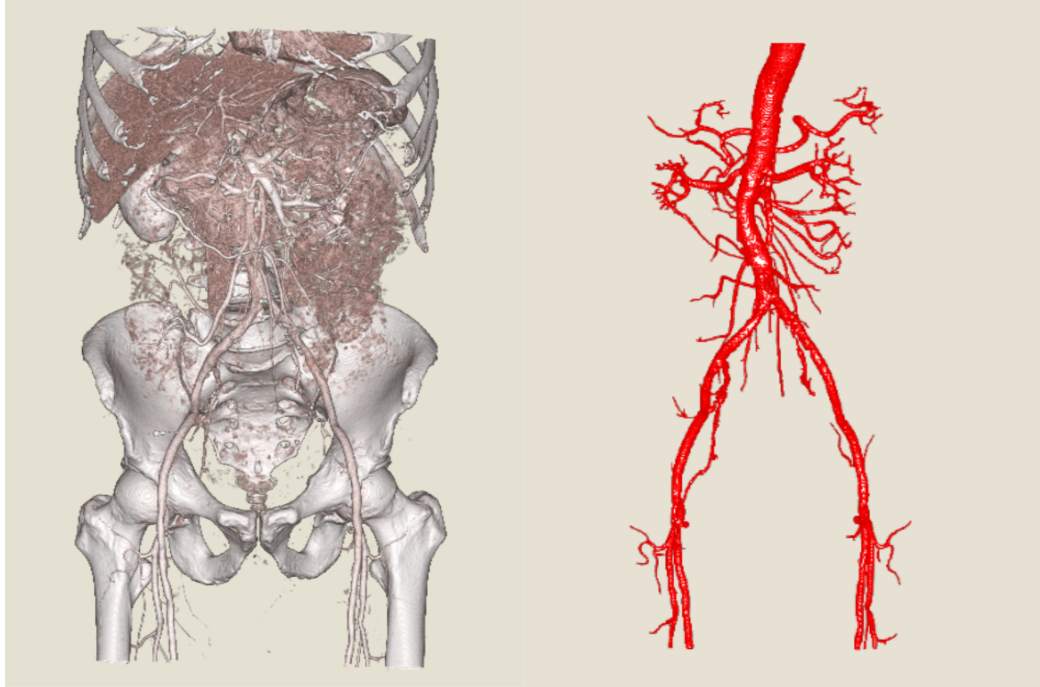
One example of abdominal blood vessels. Left is volume rendering of CE-CT data. Right is volume rendering of annotated label of blood vessel.
